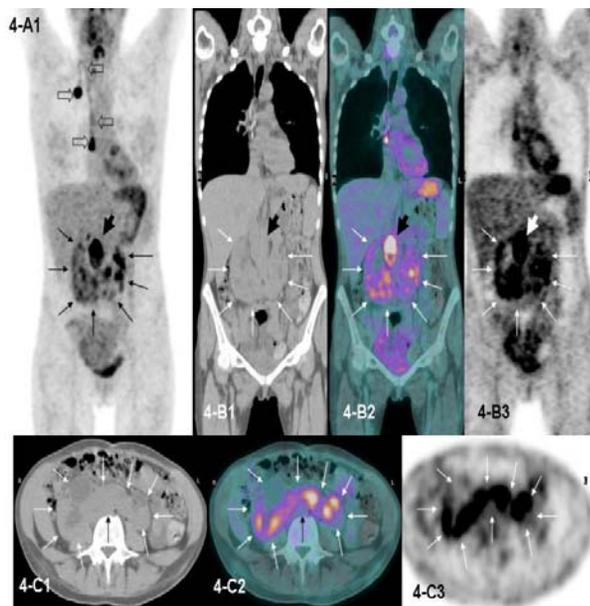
Anterior view (4-A1) of maximum intensity projection show horseshoe kidney at the central part of the abdomen (slim arrows); it's moreover visible secondary lesion at an abdominal lymph-node (big arrow) and the port-a-cath, site of injection (empty arrows). Axial CT (4-C1), fused (4-C2) and PET (4-C3) images, coronal CT (4-B1), fused (4-B2) and PET (4-B3) images show horseshoe kidney (slim arrows).
